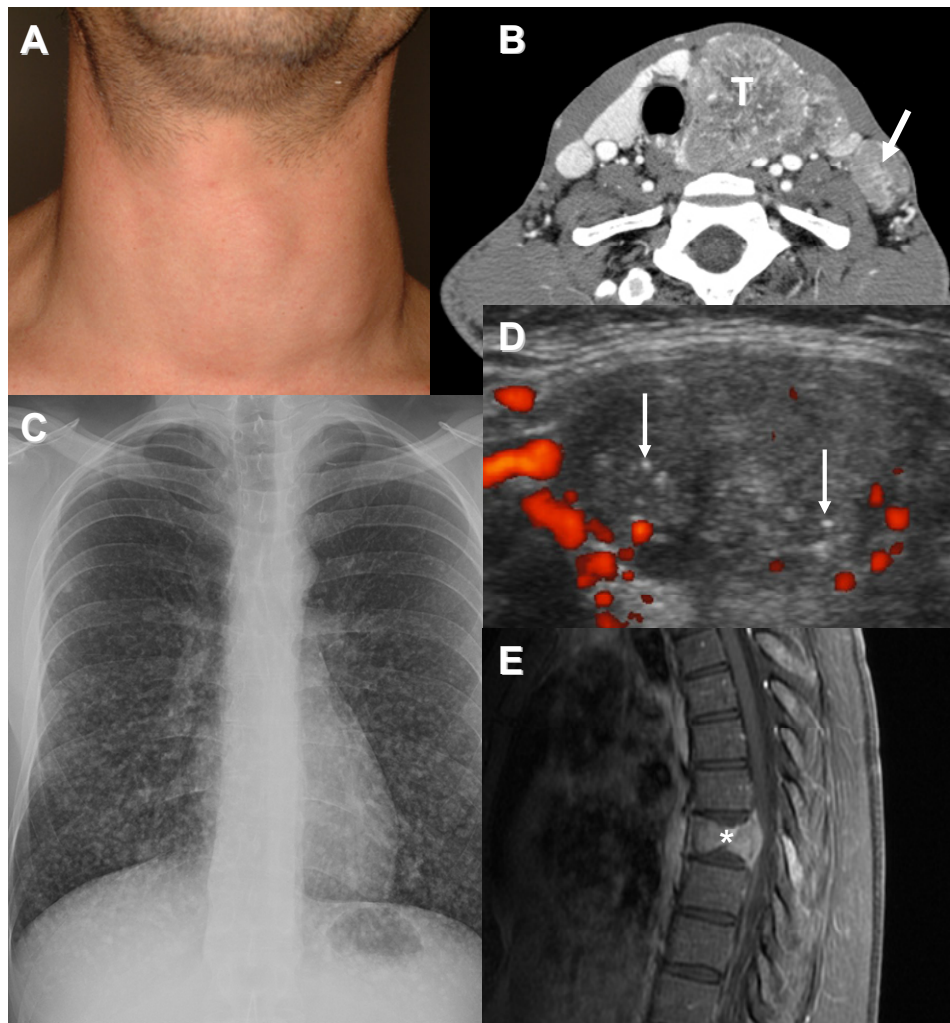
Clinical presentations of thyroid cancer. (A) A 29-year-old man with sporadic MTC presenting with a growing neck mass and diarrhea. An asymptomatic thyroid mass and/or metastatic lymphadenopathy (LAD) is the most common presentation of thyroid cancer. (B) Axial CT neck post contrast of the same patient in (A) demonstrating the primary tumor (T) and significant LAD (arrow) in the lateral neck. (C) Chest x-ray of a 36-year-old man with PTC metastatic to the lungs, recognized after a growing neck mass was diagnosed as PTC. Metastatic thyroid cancer is sometimes diagnosed via the initial finding of pulmonary metastases, which have a predilection for the lower lobes. (D) Ultrasound findings of PTC in a 34-year-old woman with a family history of PTC and thyroid nodules identified on routine physical examination. Note the solid hypoechoic appearance and presence of calcifications (arrows), which are typical for PTC. (E) Sagittal post-contrast T1-weighted MRI demonstrating a T8 metastasis (*) and pathologic compression fracture in a 35-year-old woman presenting with back pain, who was diagnosed subsequently with metastatic poorly differentiated FTC. Diagnosis of FTC after the presentation of a distant bony metastasis is not uncommon, particularly in older patients.
